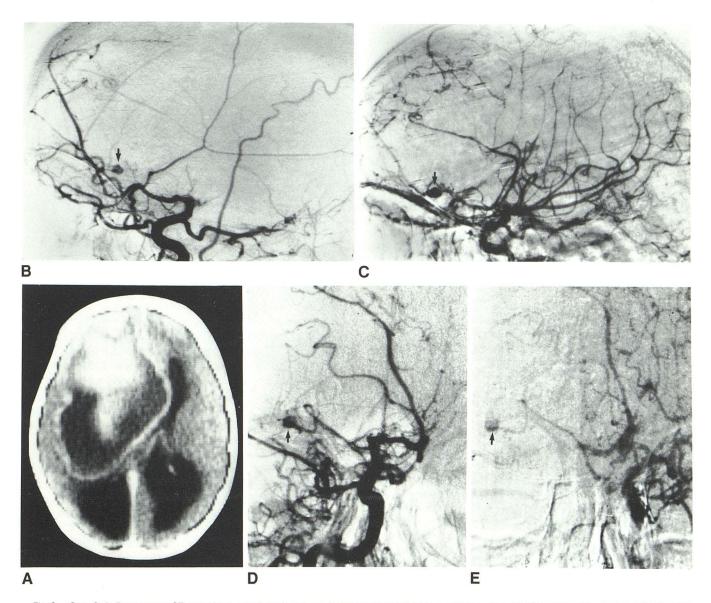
Case 2. A, Postcontrast CT scan shows very large hematoma in right cerebral hemisphere with peripheral rim of contrast enhancement, indicating that at least intracerebral hematoma is several weeks old. Lateral (B and C) and slightly oblique frontal (D and E) angiograms. Aneurysm (*arrows*) arising from inferior frontal branch, which apparently originates near anterior communicating artery and was filled during both right and left carotid injections. Right middle cerebral artery was completely occluded, with stenotic lesions in distal internal carotid artery and in both anterior and left middle cerebral arteries.
